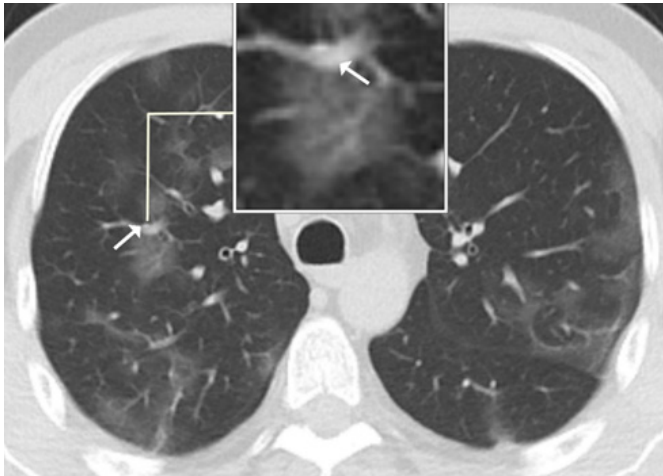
46-year-old female patient who admitted with fever, generalized body pain and back pain. No co-morbidities reported. The thorax CT axial parenchymal window image (A) shows bilateral ground-glass density nodules (arrows). Three-dimensional chest CT image of the nodules (B).
